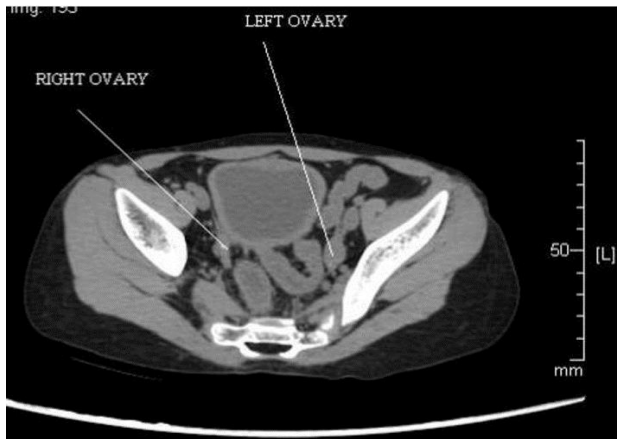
CT Abdomen shows rudimentary uterus with streak gonads.
